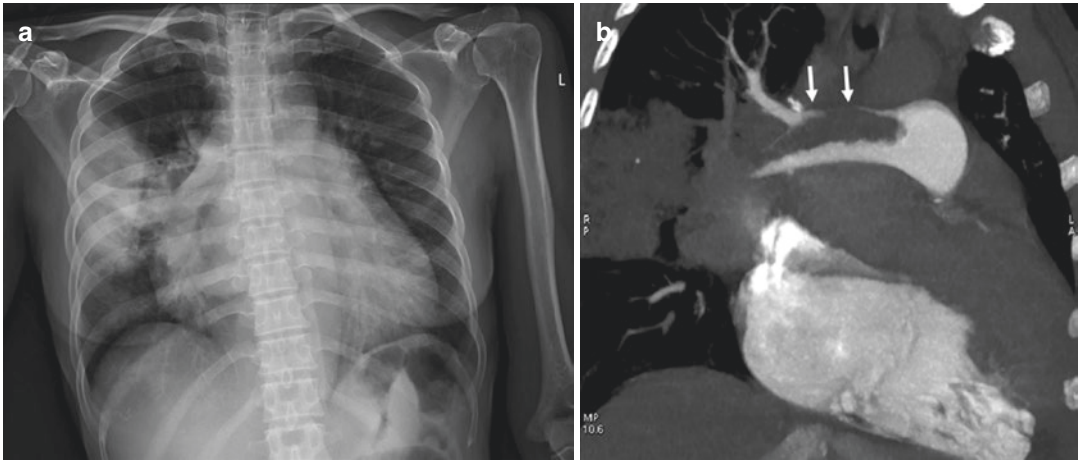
Right pulmonary embolism in a 48-year-old woman with developing sudden cough and bloody sputum. (a) Chest X-ray shows large, patchy high-density shadow in the right lung field. (b) Coronal CT reformation
